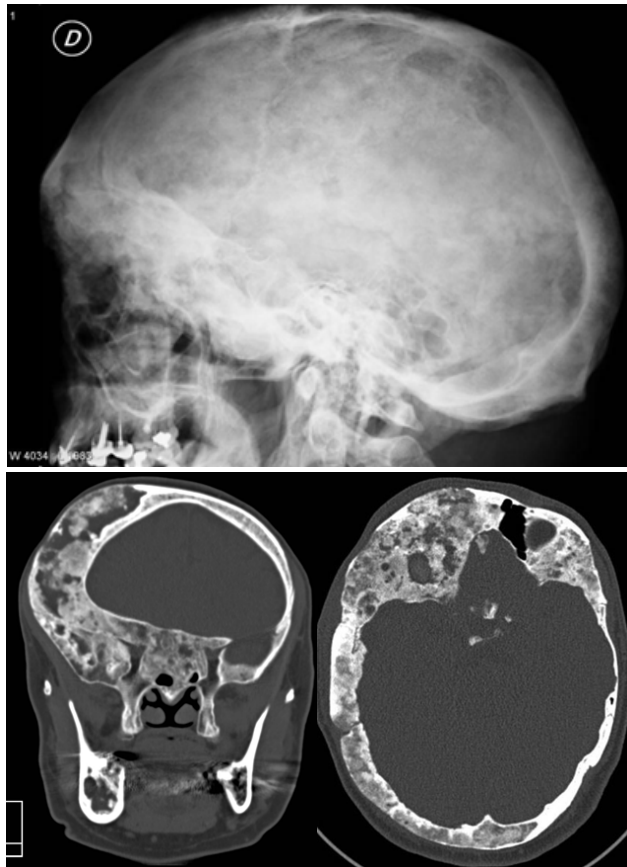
Skull CT bone window. Pseudocystic type fibrous dysplasia with skull base extension.
